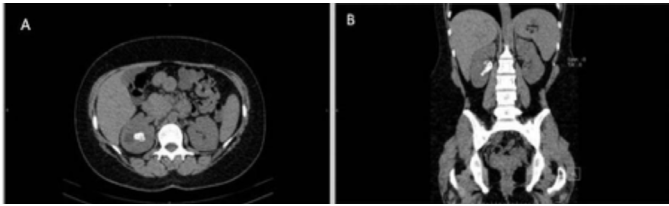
The transverse plan (a) and coronal plan (b) images of staghorn calculus in the right kidney in computed tomography
